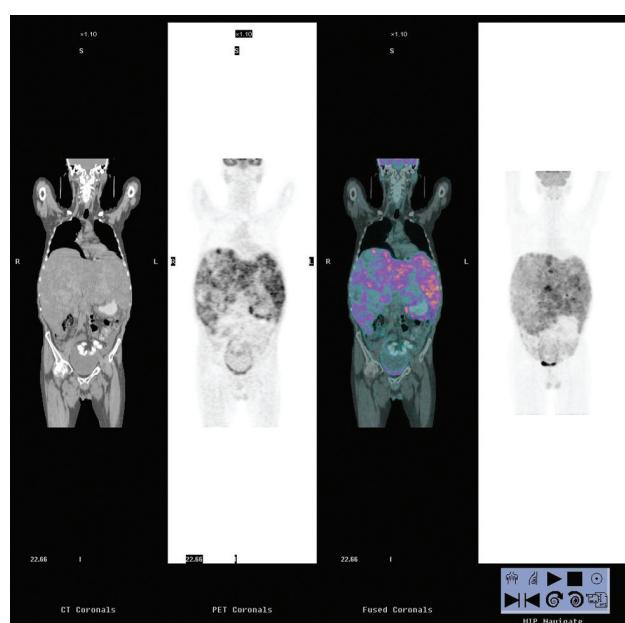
F-18 FDG PET/CT six weeks after the first therapy given to the right lobe (1.6 GBq) intra-arterially. The metabolic activity of the lesions in the right lobe was significantly decreased compared to that of lesions in the left lobe.
